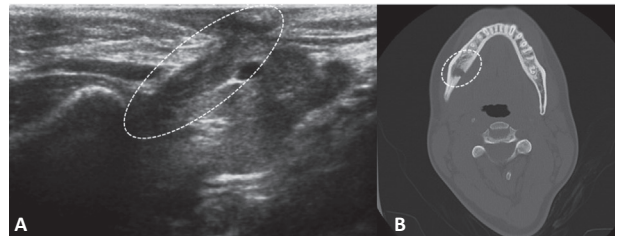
Ultrasound image showing the fistulous path (A). Computed tomography images showing a bony cortical defect at the molar region of the third and fourth quadrants, with a solution of continuity between the bone cortical and the tooth number 4.7 (B).
